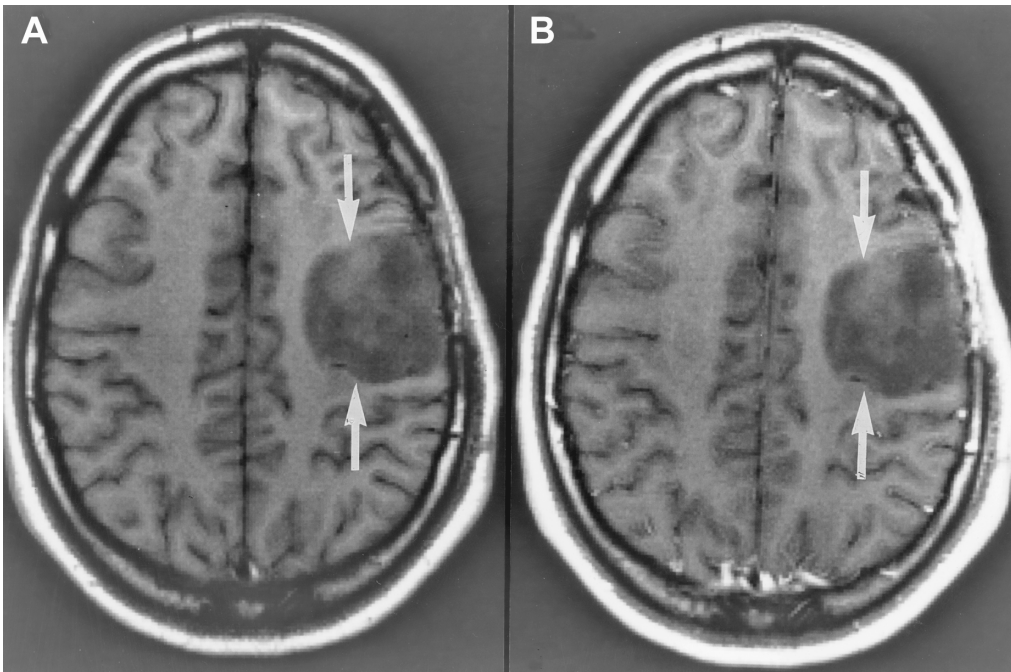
Low-grade nonenhancing astrocytoma. Pre-contrast (A) and post-contrast (B) axial MRI images show a nonenhancing tumor (arrows).
